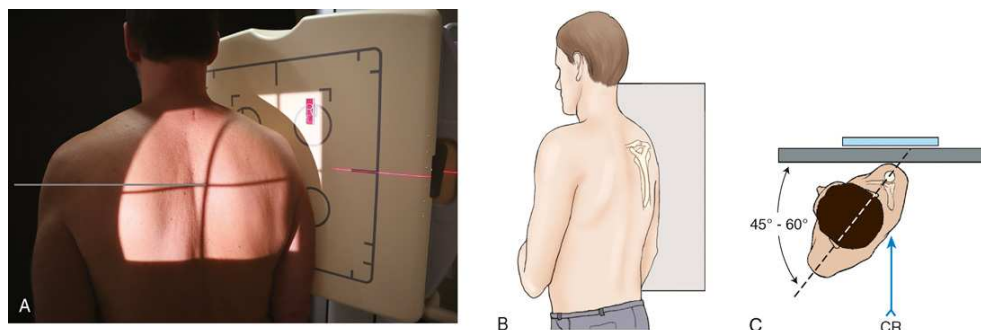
(A) PA oblique shoulder joint. (B) Perspective from x-ray tube showing scapula centered in true lateral position. (C) Top-down view showing positioning landmarks used for proper orientation of scapular body.
